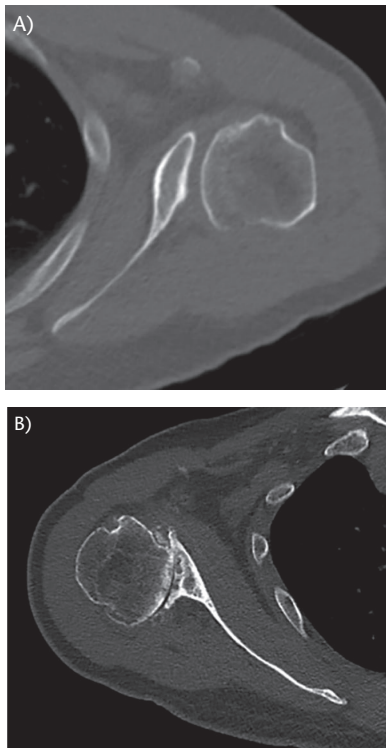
(A) Type C1 glenoid on axial CT, characterized by dysplastic glenoid retroversion greater than 25 degrees. (B) Type C2 glenoid on axial CT, characterized by a dysplastic, high premorbid glenoid retroversion in addition to degenerative posterior glenoid wear resulting in biconcavity.
